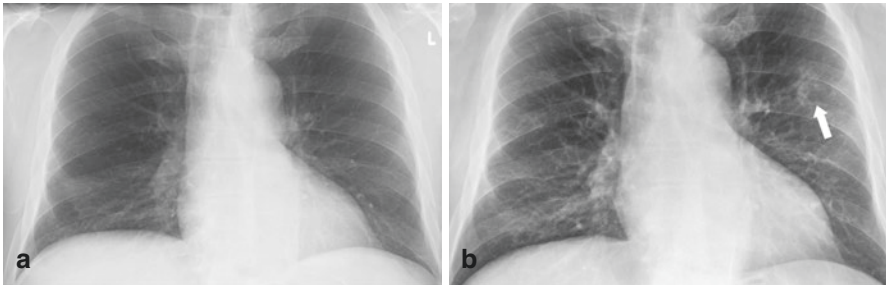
Subtle pneumonia. (a) Initial radiograph obtained several months previously is normal. (b) Subsequent study shows a small, ill-defined area of opacification in the left mid-lung (arrow). This can be identified because of asymmetry with the opposite side and a change from the initial study
